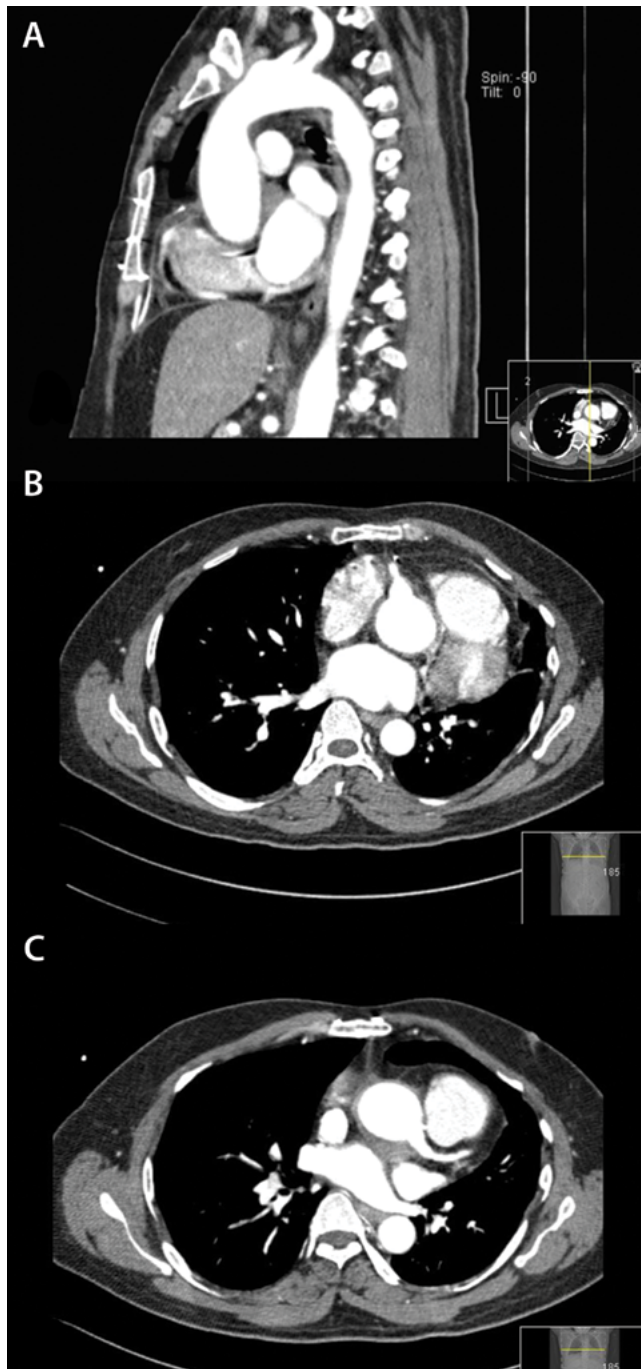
Postoperative computed tomography images obtained 10 years after surgery. *Panel A.* Sagittal section showing the neo-ascending aorta. *Panel B.* Coronal section showing the neo-right coronary artery. *Panel C.* Coronal section showing the neo-left coronary artery.
